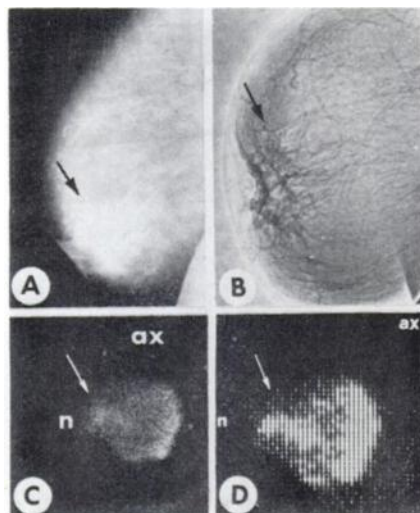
Mediolateral mammography (A), mediolateral xeroradiography (B), and lateral ^{99m}Tc -pertechnetate breast scintigraphy (C) reveal carcinoma in left breast. Computer histogram (D) shows more extensive lesion confirmed at surgery.
